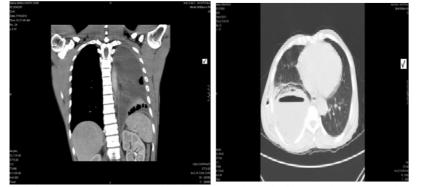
Loculated left sided empyema, Figure 3: Loculated effusion with air fluid level with enhancing thick pleura on computed tomography
